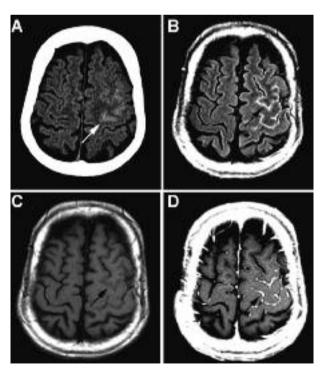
Non-contrast CT (A) and corresponding FLAIR (B), T1 (C), and postcontrast T1 (D) weighted MRI indicating gyriform lesion (arrows).
